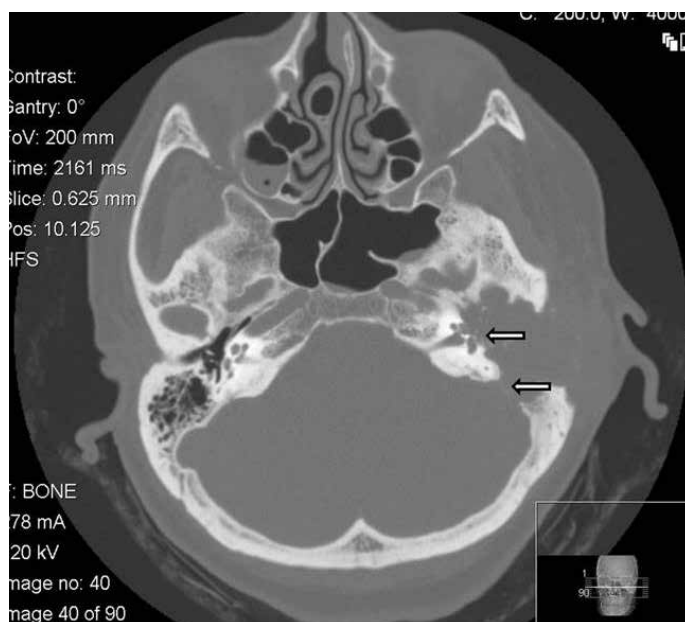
Postoperative axial CT scan. Arrows denote bony erosion of the cochlea and over the sigmoid sinus
